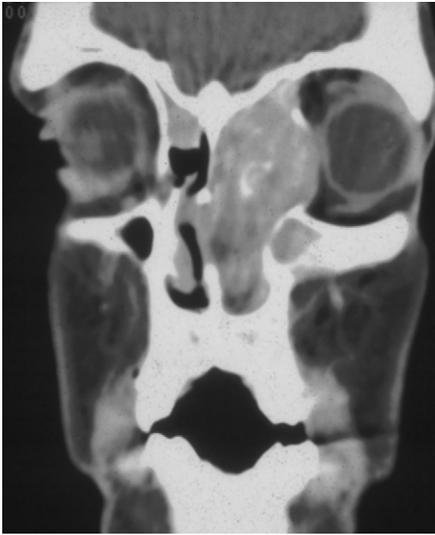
Coronal CT image of patient in Fig. 30-10. Note calcification in maxillary-ethmoid mass highly suggestive of aspergilloma.
